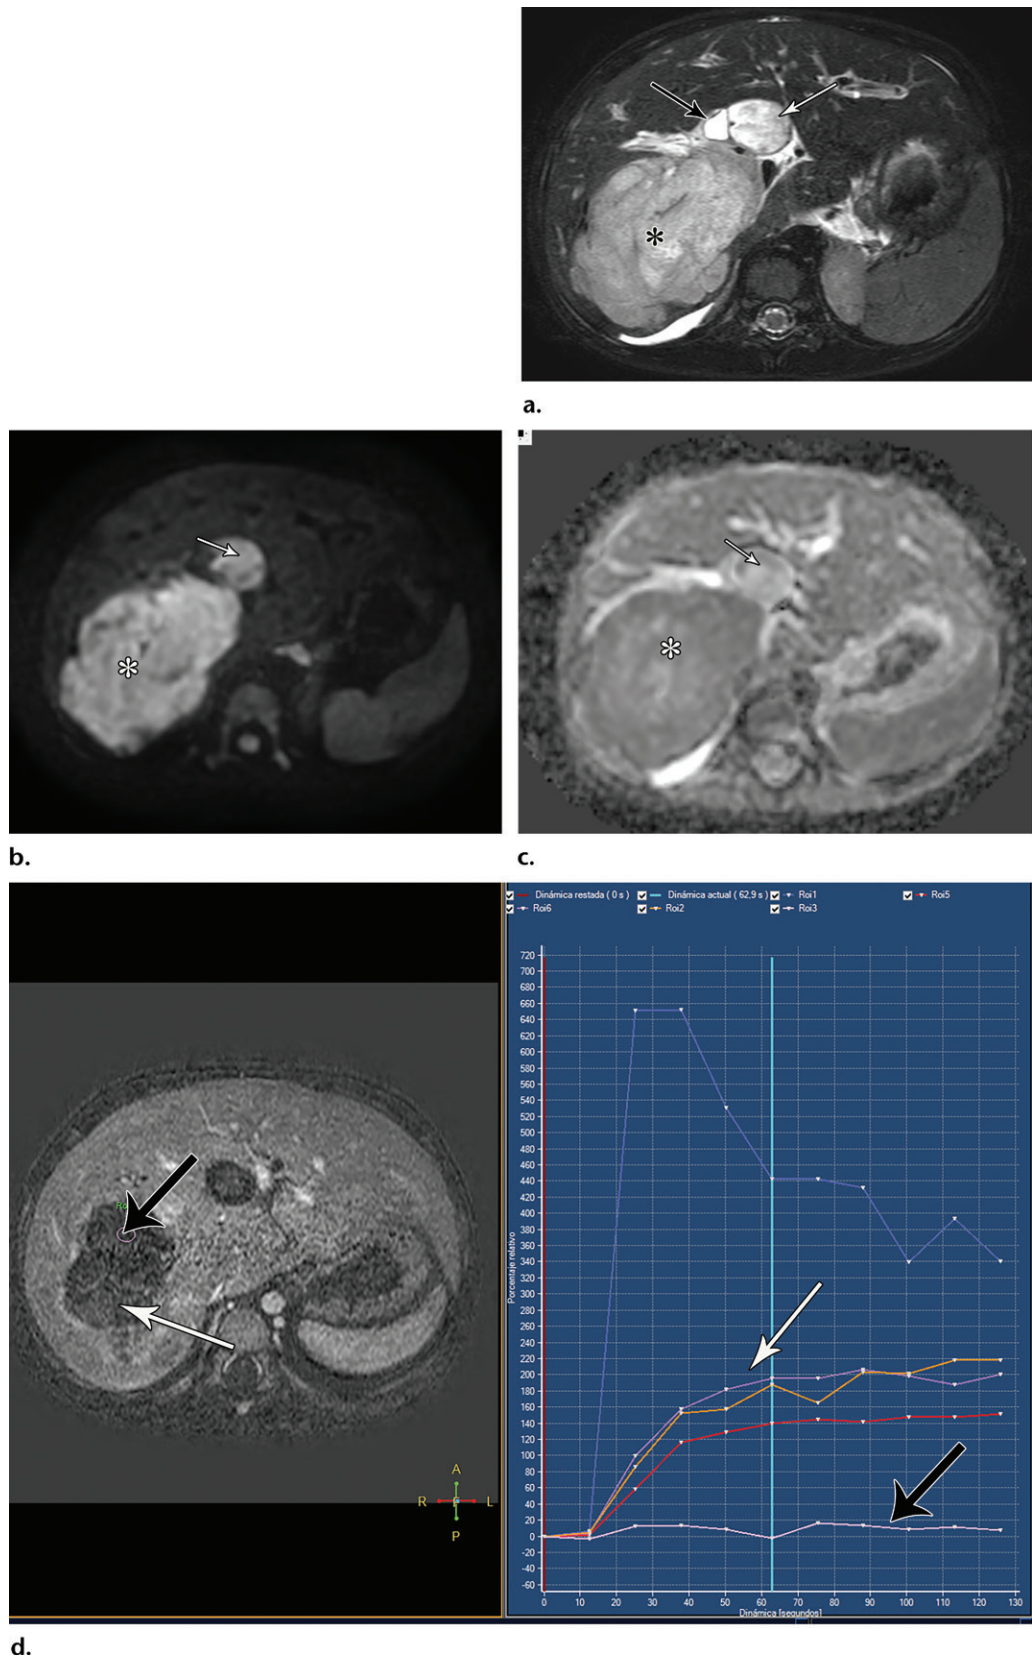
Embryonal rhabdomyosarcoma (botryoid variant) of the liver in a 3-year-old boy. (a) Axial fat-suppressed T2-weighted image shows a heterogeneously hyperintense liver mass (*) with lobulated margins. The lesion involves and expands the common bile duct (CBD) (white arrow) in association with proximal dilatation of the biliary tree (black arrow). (b, c) Axial diffusion-weighted image (b) and ADC image (c) show restricted diffusion of the mass (*) and of the tumoral component in the CBD (arrow). (d) Left: DCE image shows heterogeneous enhancement of the mass (white arrow). The mass also contains areas of necrosis (black arrow). Right: The heterogeneous enhancement correlates with a type III or IV TIC profile (white arrow). The areas of necrosis correlate with a type I curve profile (black arrow). Blue curve = reference standard of arterial uptake.
